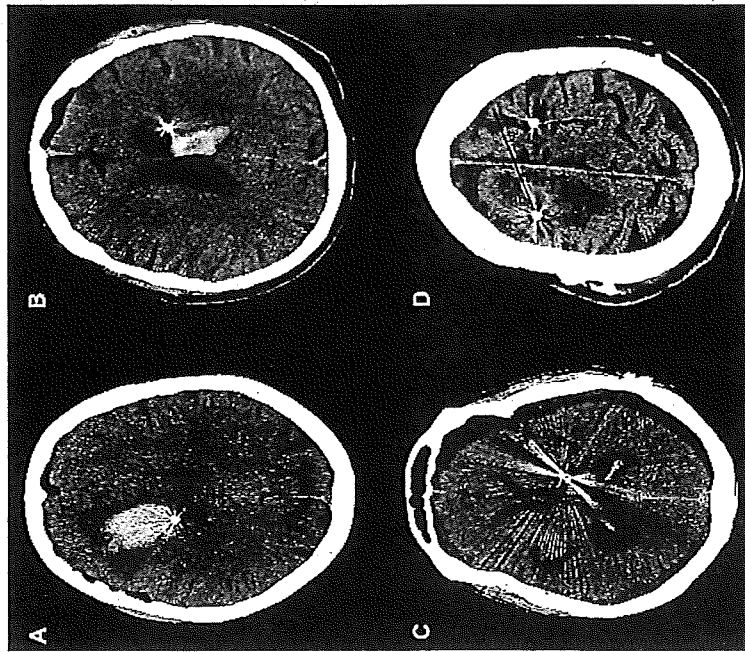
Computed tomography (CT) scan images of the many types of hemorrhage that may be encountered following DBS lead implantation. This panel of CT images reveals examples of intracerebral hemorrhage (A), intraventricular hemorrhage (B), subdural hemorrhage (C), and venous infarction (D).
